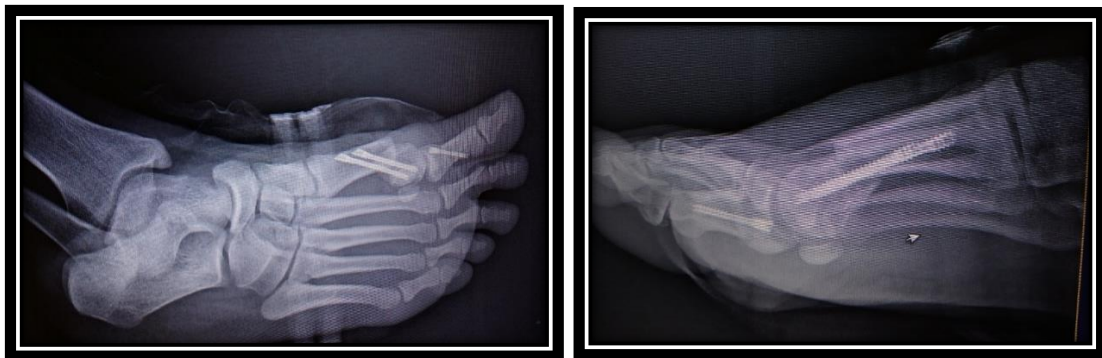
X-ray view (profile and ¾) of foot after chevron percutaneous osteotomy
